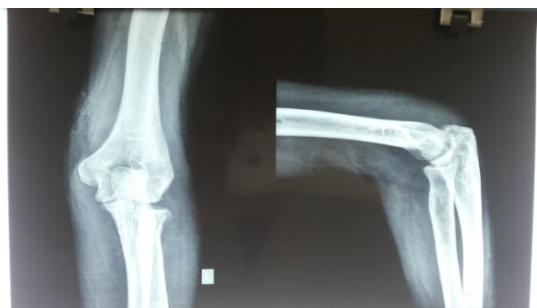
Anteroposterior and lateral radiographs showing reduced elbow after the removal of LRS
